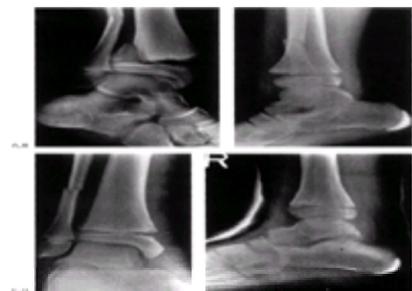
Pronation and external rotation ankle fracture. A: The anteroposterior radiograph demonstrates a Salter-Harris type II fracture of the distal tibia. The Thurston-Holland fragment is lateral. The fibular fracture is transverse and located well above the fibular physis. B: Lateral projection of the same injury. C: This fracture was treated with closed reduction and application of an above-knee cast. D: A lateral radiograph demonstrates acceptable alignment. This fracture was managed successfully with closed reduction.
